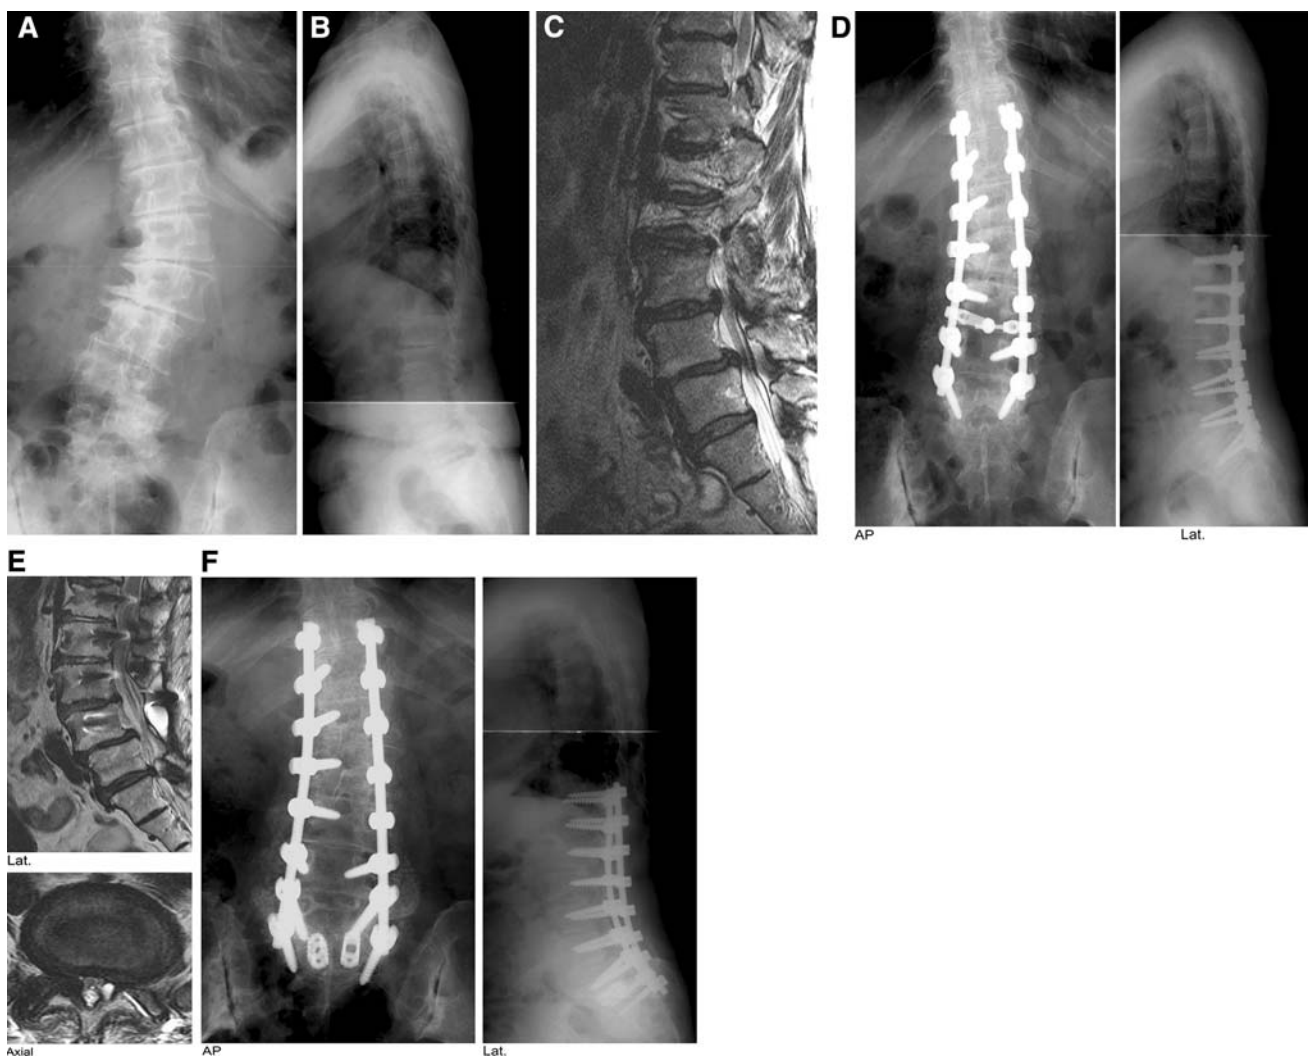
a This 72-year-old lady had degenerative lumbar scoliosis. b Standing preoperative sagittal radiograph showed C7 plumb shifted to anterior about 10 cm and showed a healthy L5-S1 disc. (Grade 1 disc degeneration by modified Weiner method). c Preoperative MRI also showed a minimal degenerated L5-S1 disc. d As the L5-S1 disc
